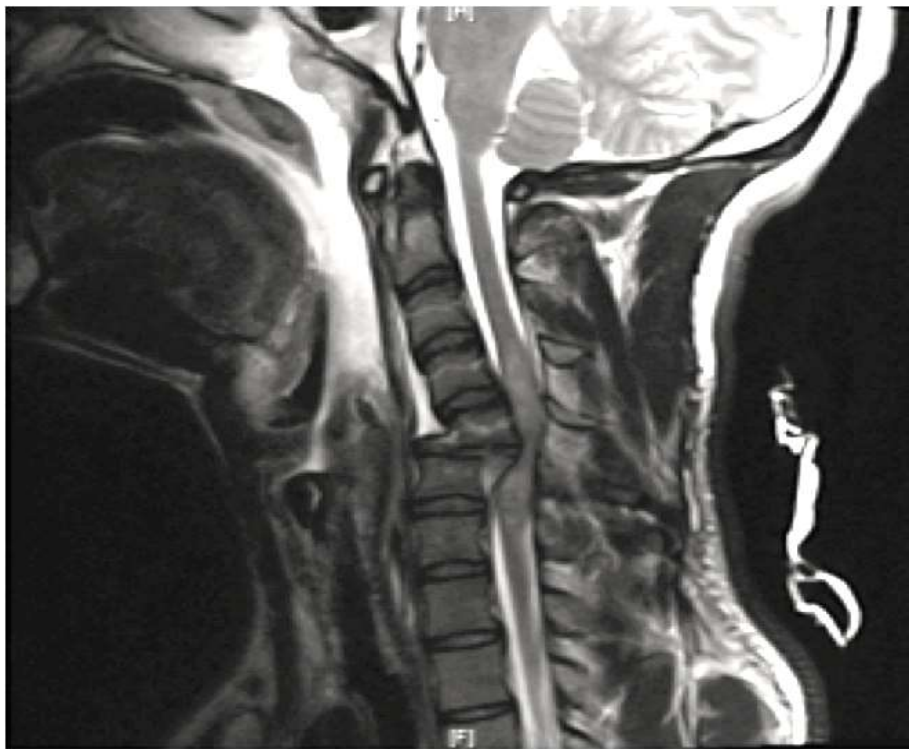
Magnetic resonance imaging (MRI) of cervical spinal cord injury at level of C4. The image shows protrusion of vertebrae towards spinal cord causing compression. Adopted from <https://www.orthobullets.com>.
